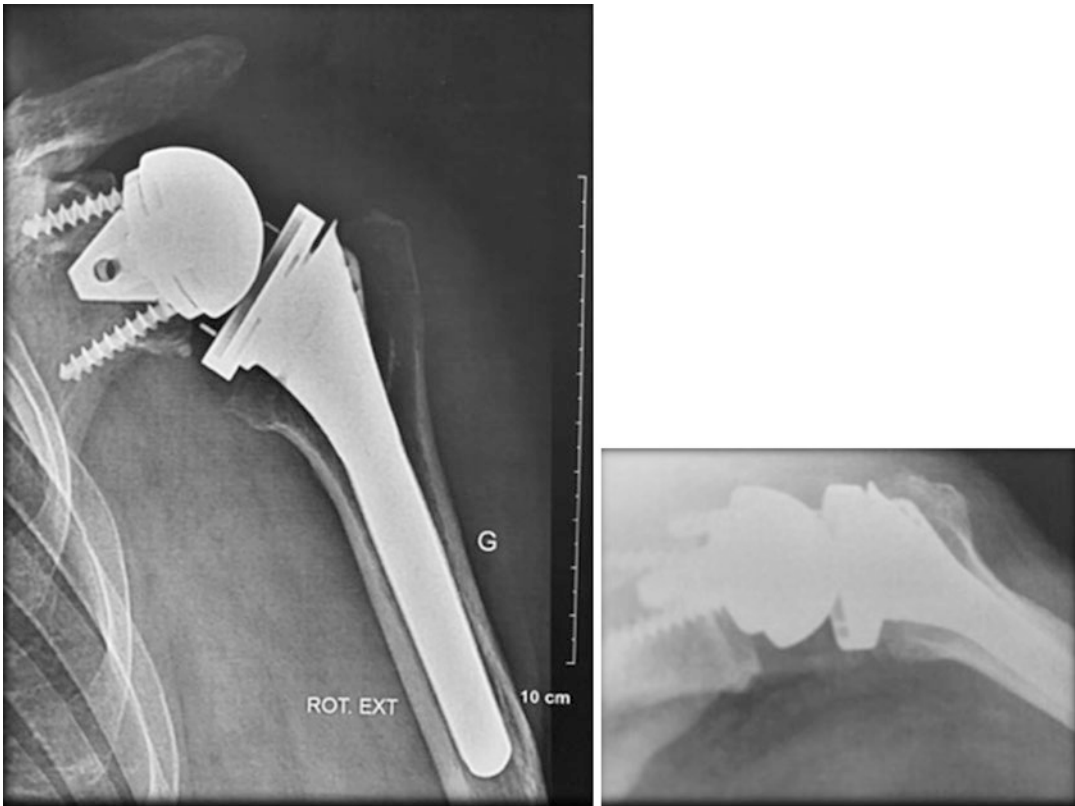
Case 1; x-ray of the shoulder after surgical treatment with reverse shoulder arthroplasty
